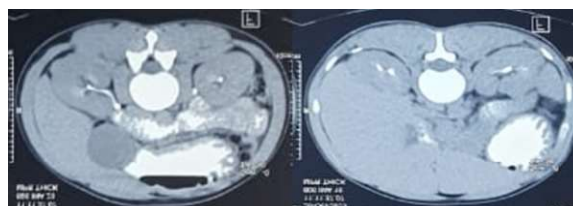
CT scan of abdomen
